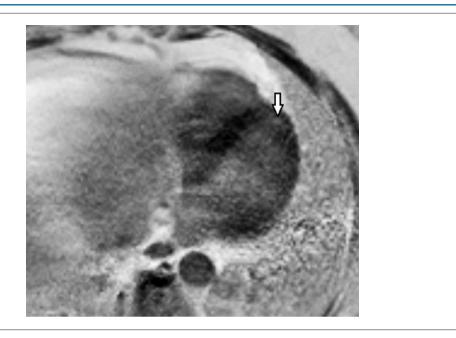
There is a focal lesion in four-chamber PSIR prepared gadolinium-enhanced T1-weighted image. Focal lesion localized to the apical region of the left ventricle, showing late subendocardial- myocardial enhancement compatible with fibrosis.
